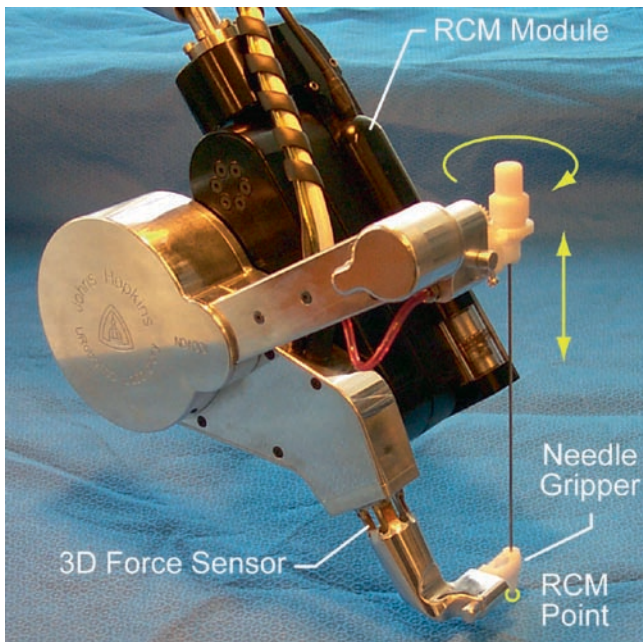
Revolving needle driver (RND) connected to the AcuBot CT-guided robot for needle positioning and orientation
